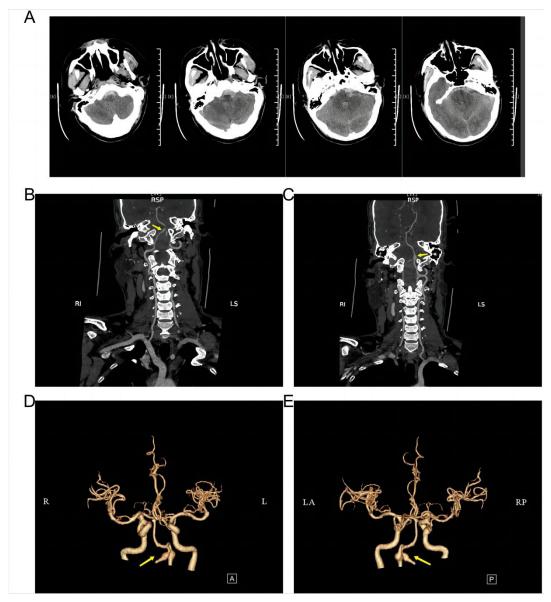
Preoperative CTA imaging. (A) Plain CT scan image of the head. (B-C) Coronal CTA images of the head and neck. (D-E) CTA reconstruction pictures of the head.
